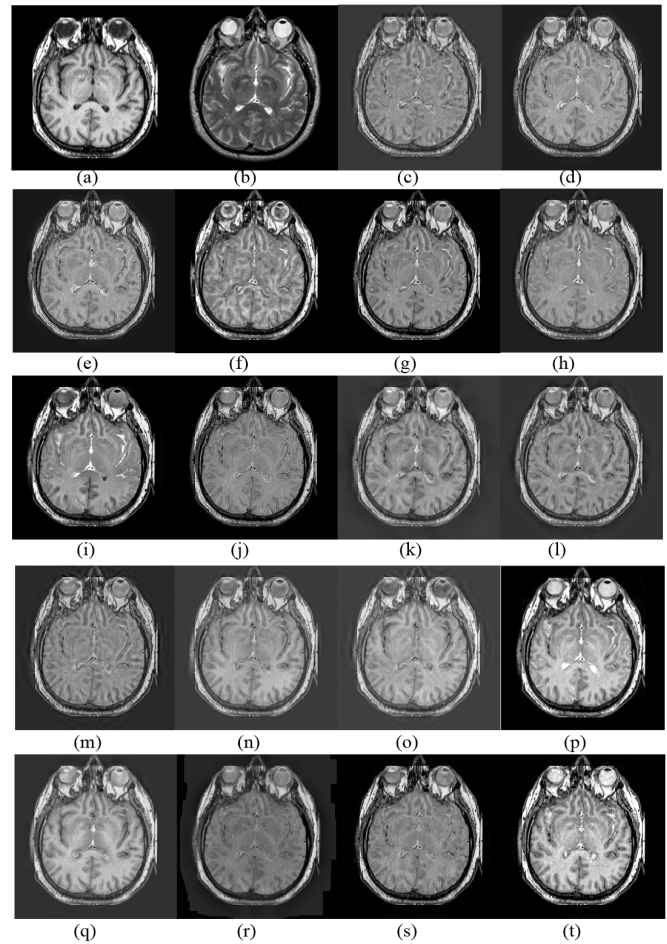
Experiments for S7. (a) CT. (b) MRI. (c) GP [52]. (d) DWT [52], [53]. (e) fsdP [52]. (f) GFS [54]. (g) CSR [55]. (h) ASR [56]. (i) GFF [57]. (j) MSVD [58]. (k) DTDWT [59]. (l) SWT [60], [61]. (m) CVT [62]. (n) DTCWT-SR [63]. (o) CVT-SR [63]. (p) LRSDL [64]. (q) PCLLE [65]. (r) MSGIF [66]. (s) DCHWT [67]. (t) Proposed.
